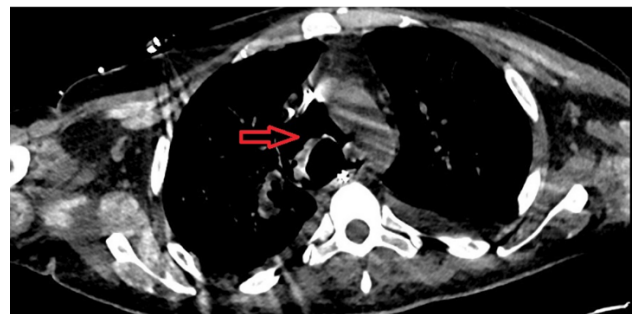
CT Thoracic scanner highlights the complete dehiscence of the anterior wall of the trachea just above the carina, with appearance of pneumomediastinum and pneumopericardium.
